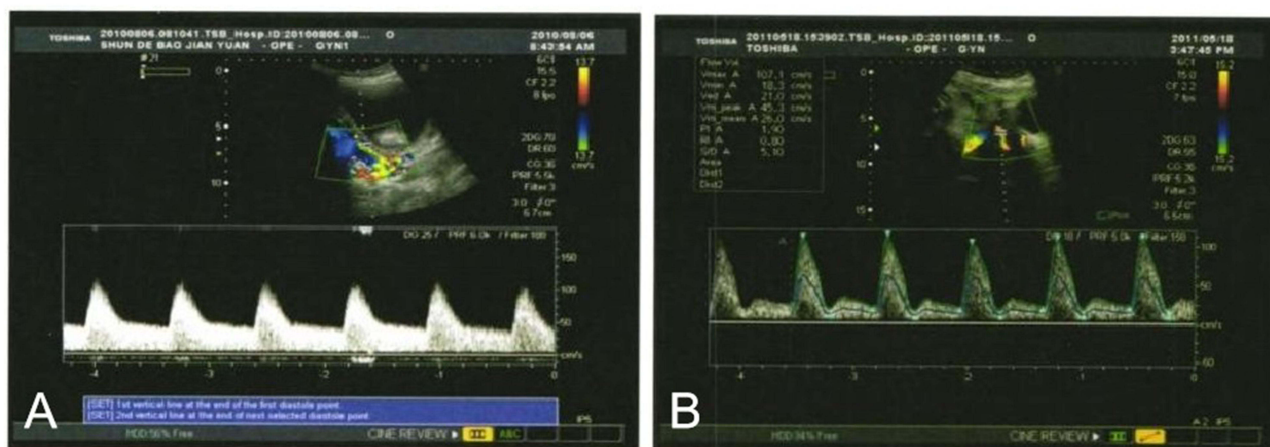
Uterine Artery Doppler at 27+6 Weeks (A) Control: Low-resistance flow (normal) (B) PE: Elevated resistance with diastolic notch.
